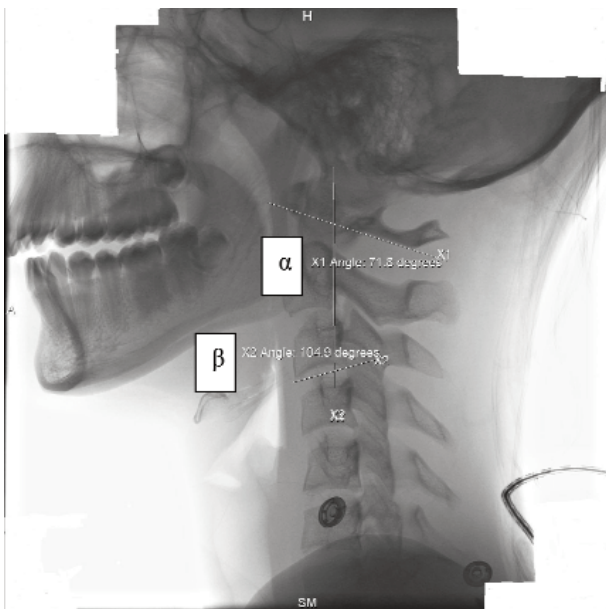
Lateral cervical spine radiograph: reference lines and the angles in the neutral position before intubation.
